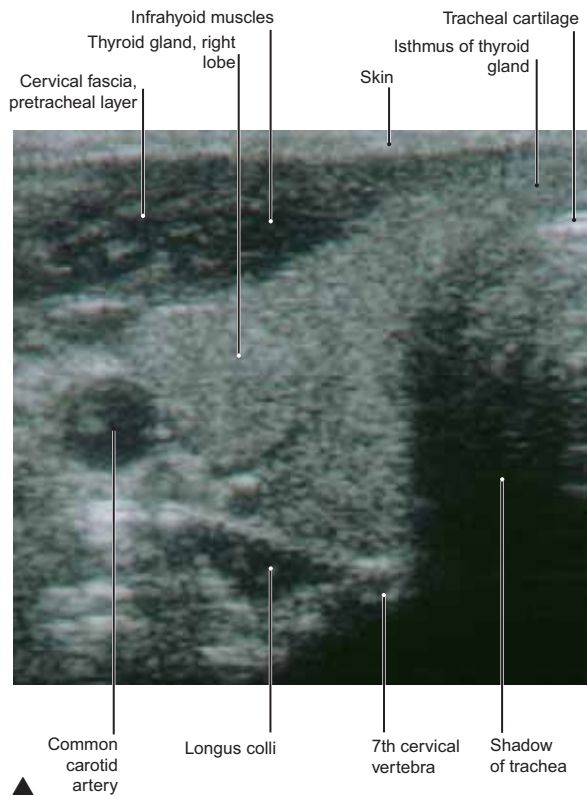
Ultrasound Scan of the Thyroid Gland
